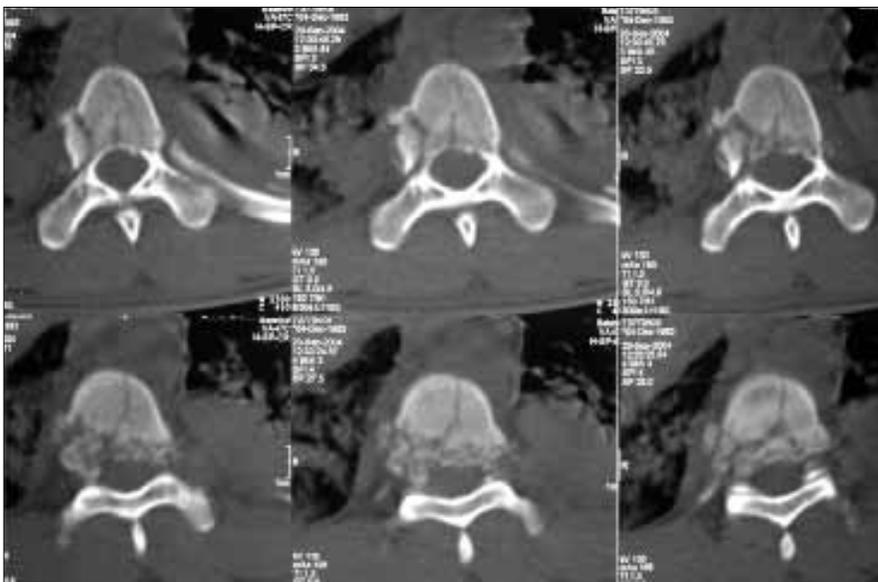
CT scan of the shattered seventh thoracic vertebra, indicating tract of the bullet from the left to the right.
